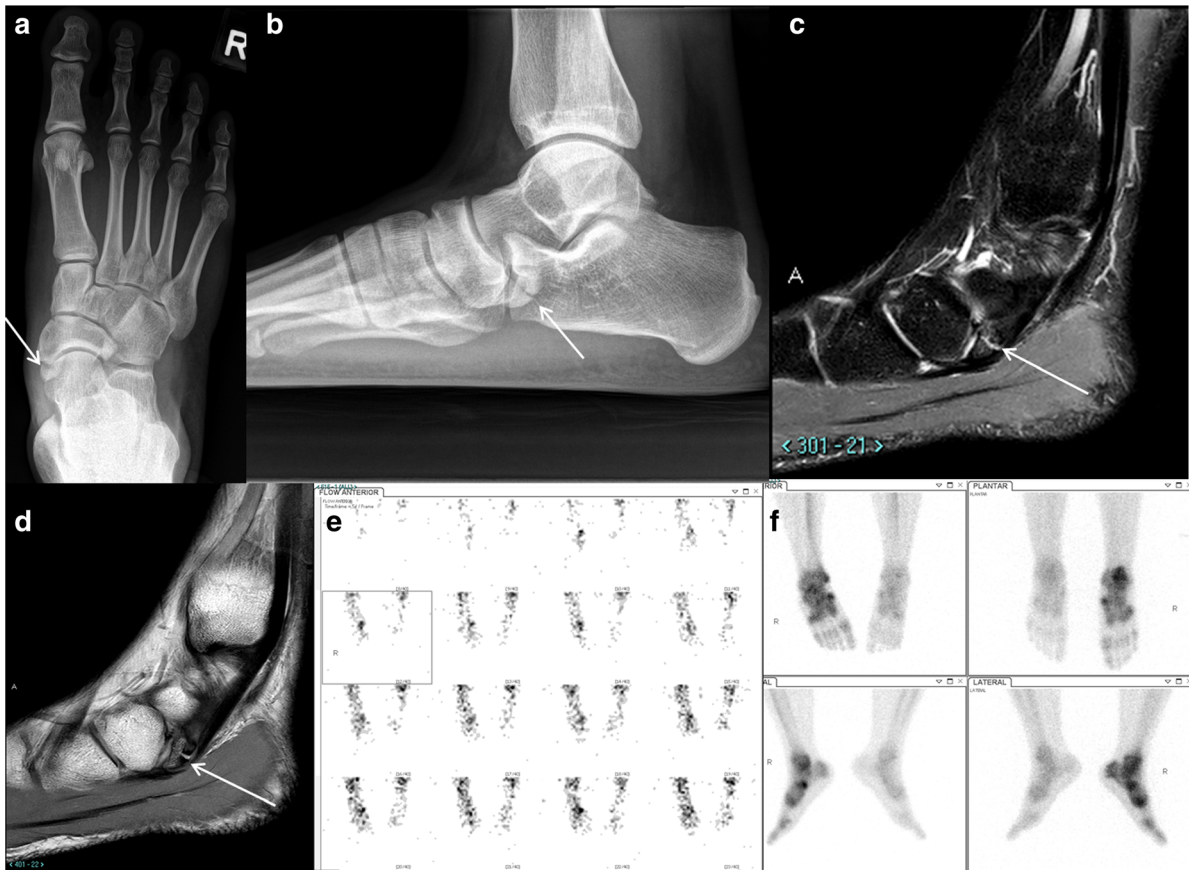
Frontal (a) and lateral (b) radiographs of the foot show a split type 2 accessory navicular with poorly corticated margins (arrow). Sagittal T2-weighted fat-suppressed (c) and proton density (d) MR images confirms the presence of a fluid-filled fracture cleft within the accessory navicular (arrow) with adjacent marrow edema. Blood flow (e)
